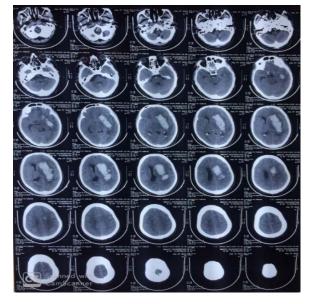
CT-scan image of patient no. 2
